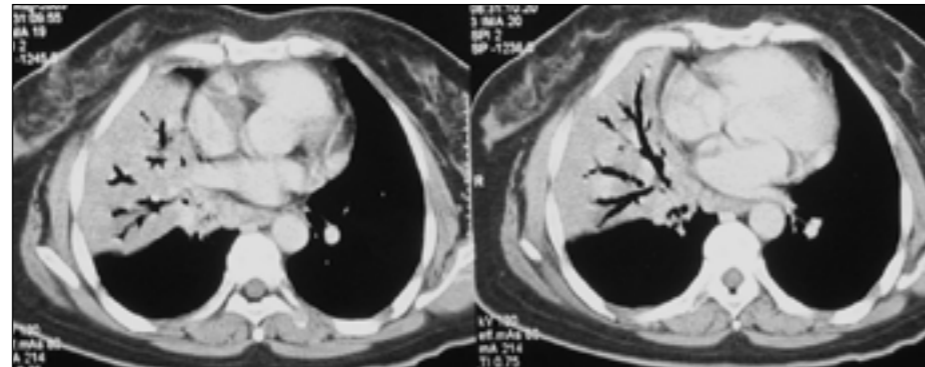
Contrast enhanced computed tomogram of thorax showing consolidation in the right middle lobe extending to the periphery of the lung with an air-bronchogram.
